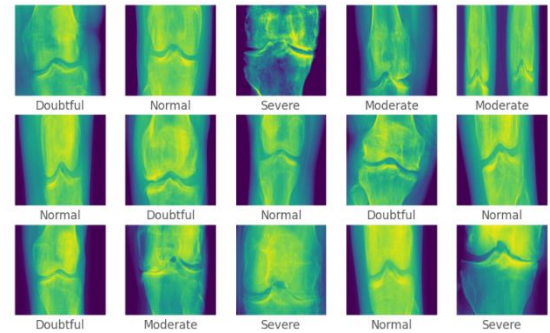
Labelled X-ray Image Data
